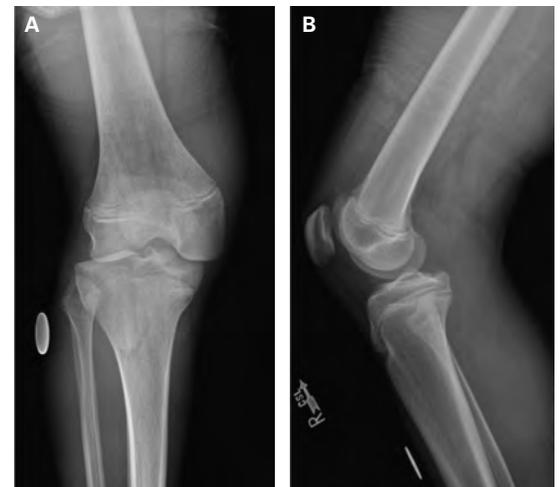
Initial AP (A) and lateral (B) radiographs demonstrating lateral femorotibial dislocation.
